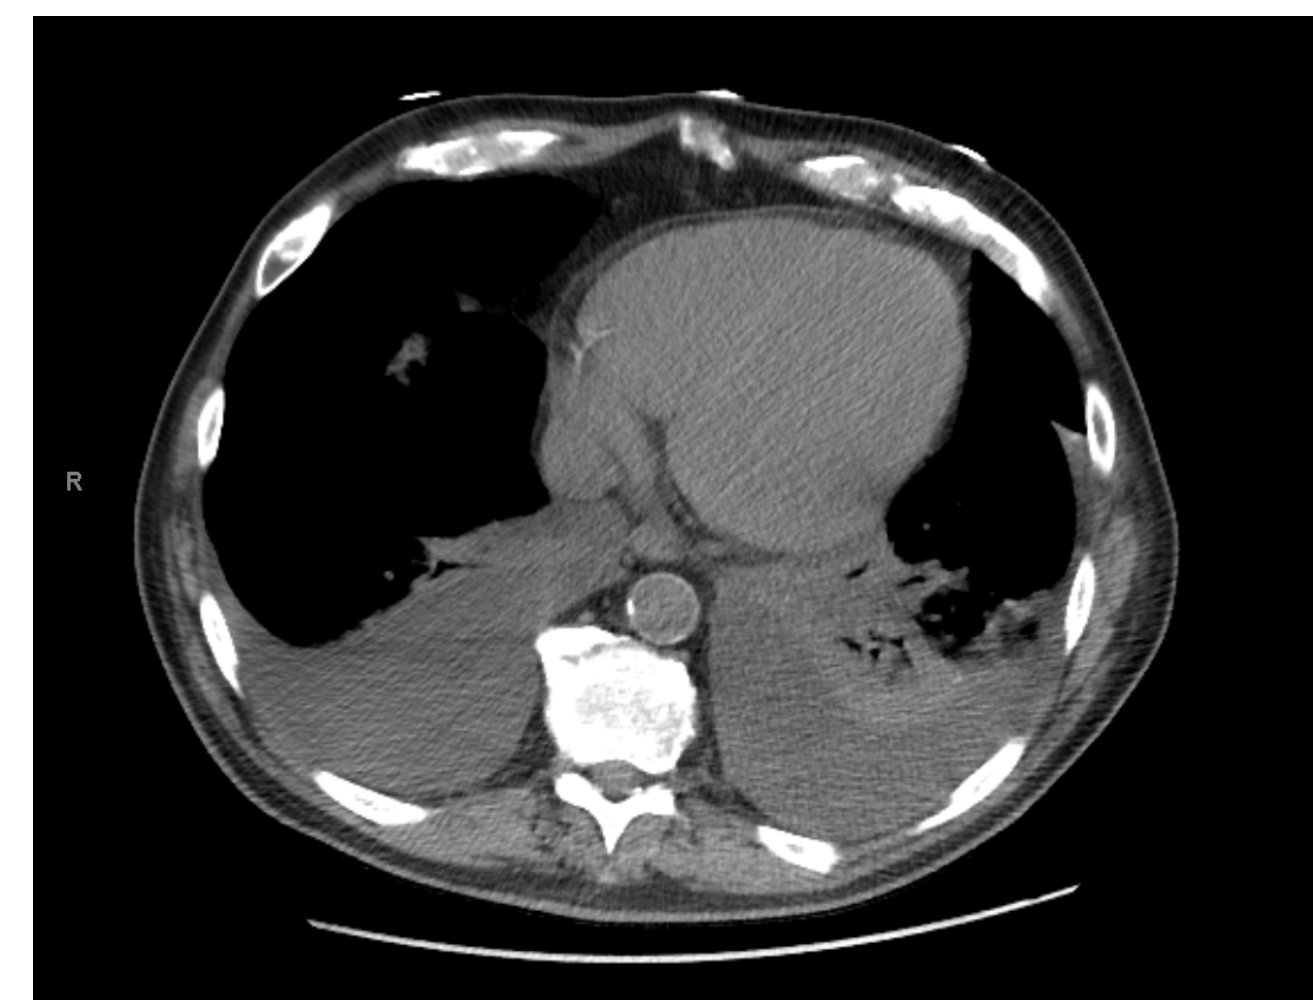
CT demonstrating large bilateral pleural effusion
